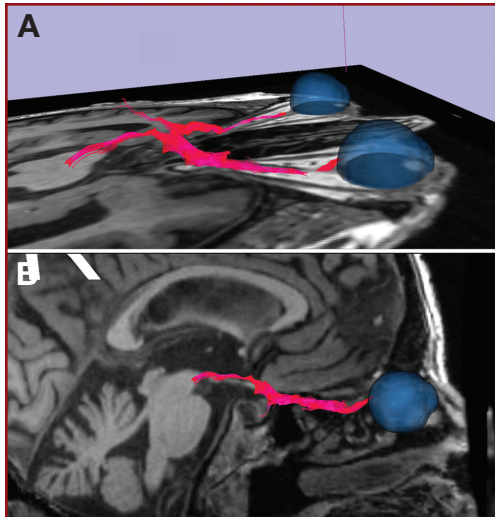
Three-dimensional tract reconstruction for the optic apparatus, overlaid onto anatomic 3-T magnetic resonance imaging (MRI) slices. A, the optic nerve, chiasm, and optic tract. The globe has been outlined in blue as a separate volume. The angle of the chiasm compared with the optic nerve can be visualized. B, the same structures overlaid onto sagittal MRI sequences. (Please see also Supplemental Digital Content 1, Figure 1, a 3-dimensional representation of the optic chiasm, optic radiation, and Meyer's loop <http://links.lww.com/NEU/A291>.)
